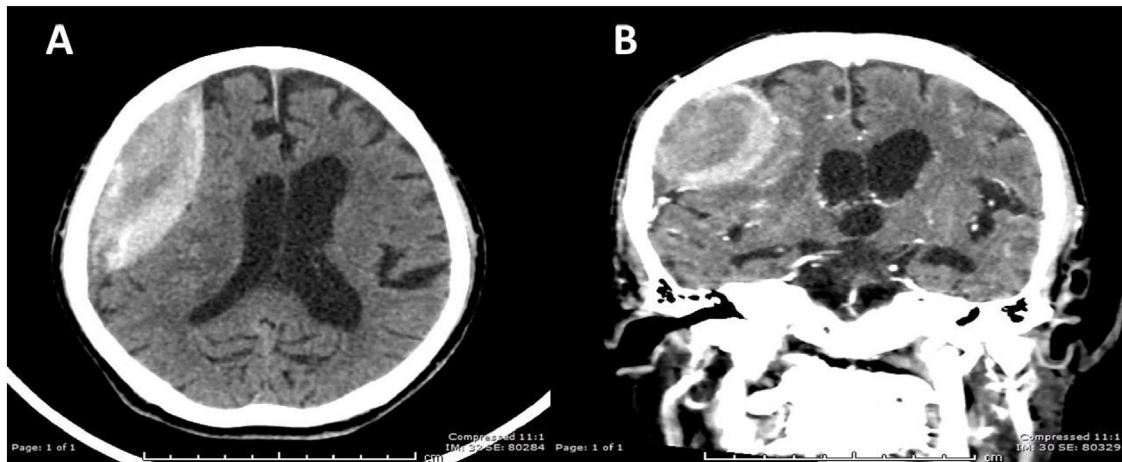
CT scan revealed biconvex heterogenous hypodensity extra-axial collection about $3.4 \times 8.2 \times 4$ cm with thickened rim calcification along right frontoparietal convexity and right coronal suture in transverse (A) and coronal (B) view.
